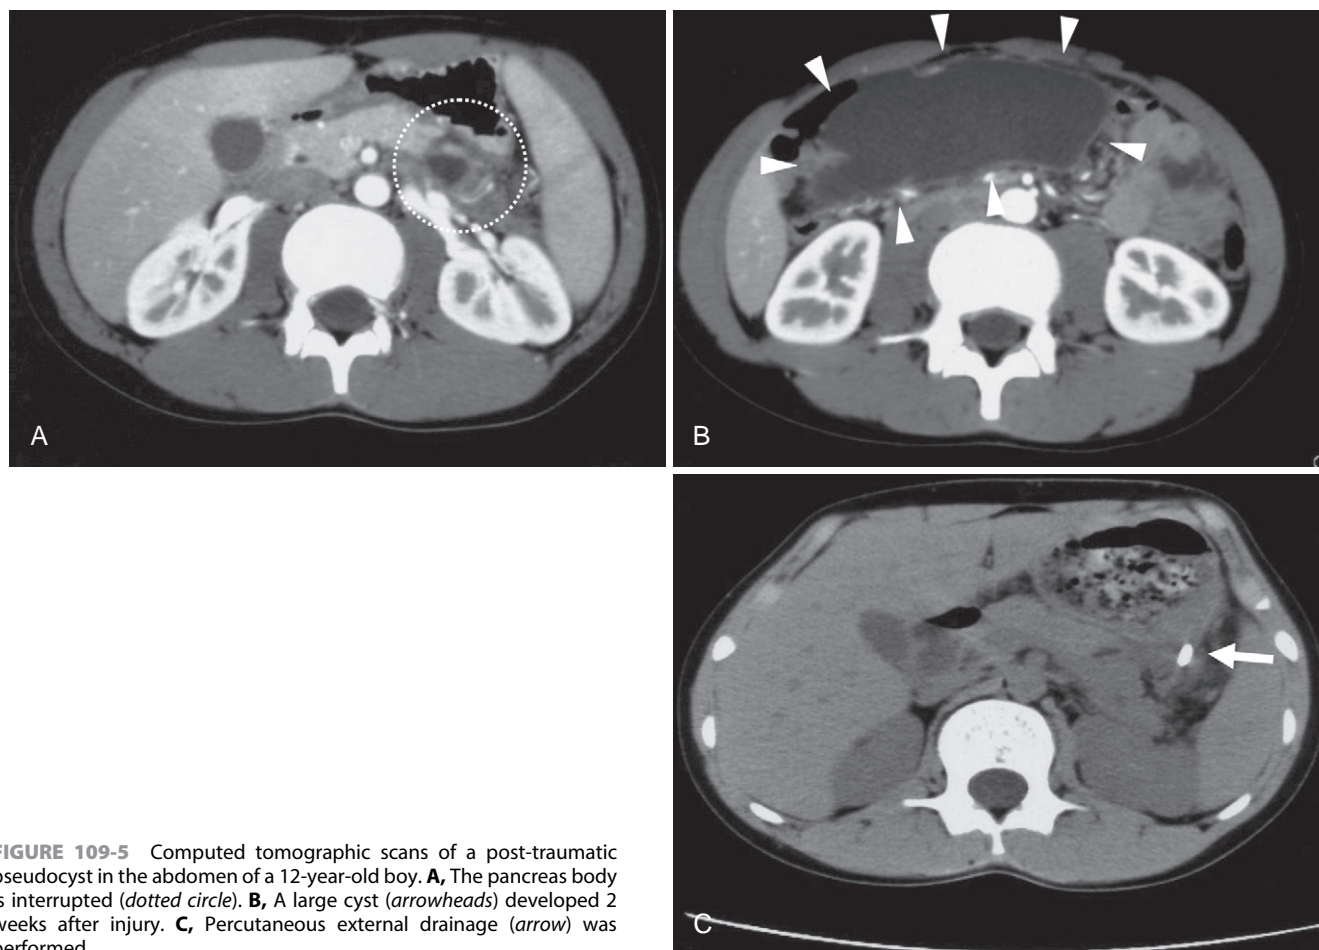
Computed tomographic scans of a post-traumatic pseudocyst in the abdomen of a 12-year-old boy. A, The pancreas body is interrupted (dotted circle). B, A large cyst (arrowheads) developed 2 weeks after injury. C, Percutaneous external drainage (arrow) was performed.
